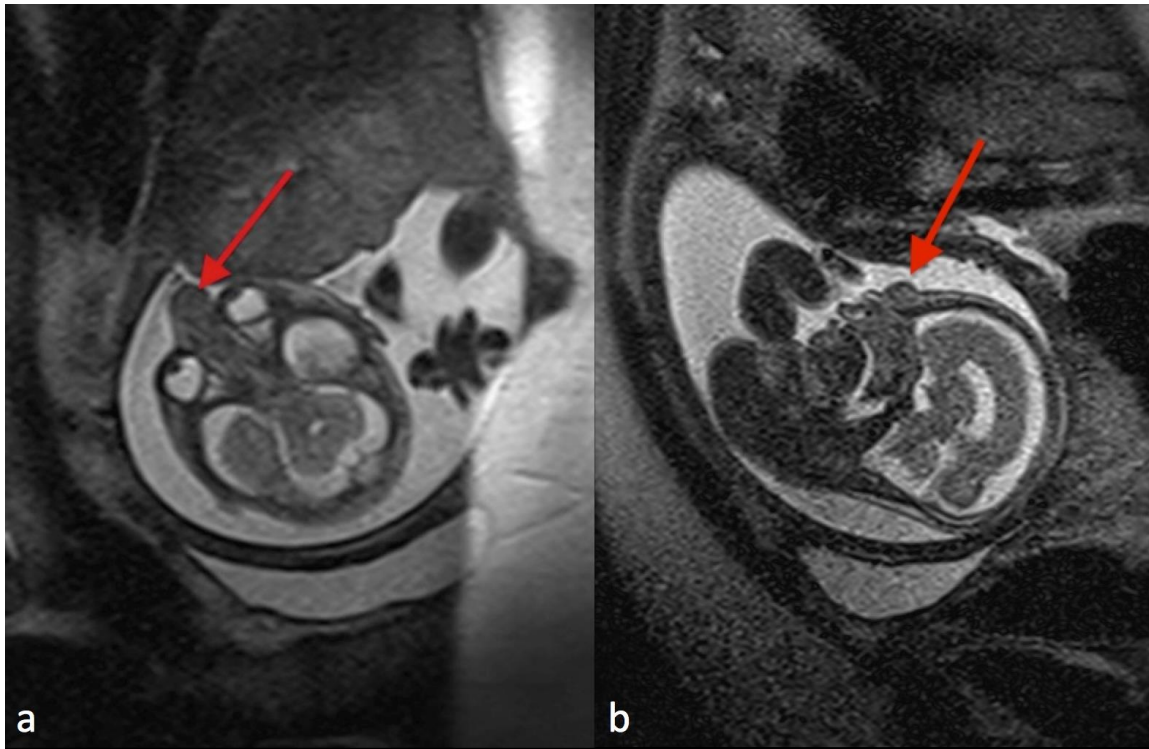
Female fetus at 21 weeks gestation with nasal glioma. Axial (a) and sagittal (b) T2-weighted MRI demonstrates a frontonasal mass (red arrow) that is isointense to brain parenchyma with no definite connection to the intracranial structures. Technique: 1.5 T magnet strength, Avanto MR, Siemens, Germany, axial T2 sequence 1100 TR, 105 TE, 3.0 mm slice thickness; sagittal T2 sequence 1100 TR, 108 TE, 2 mm slice thickness.
